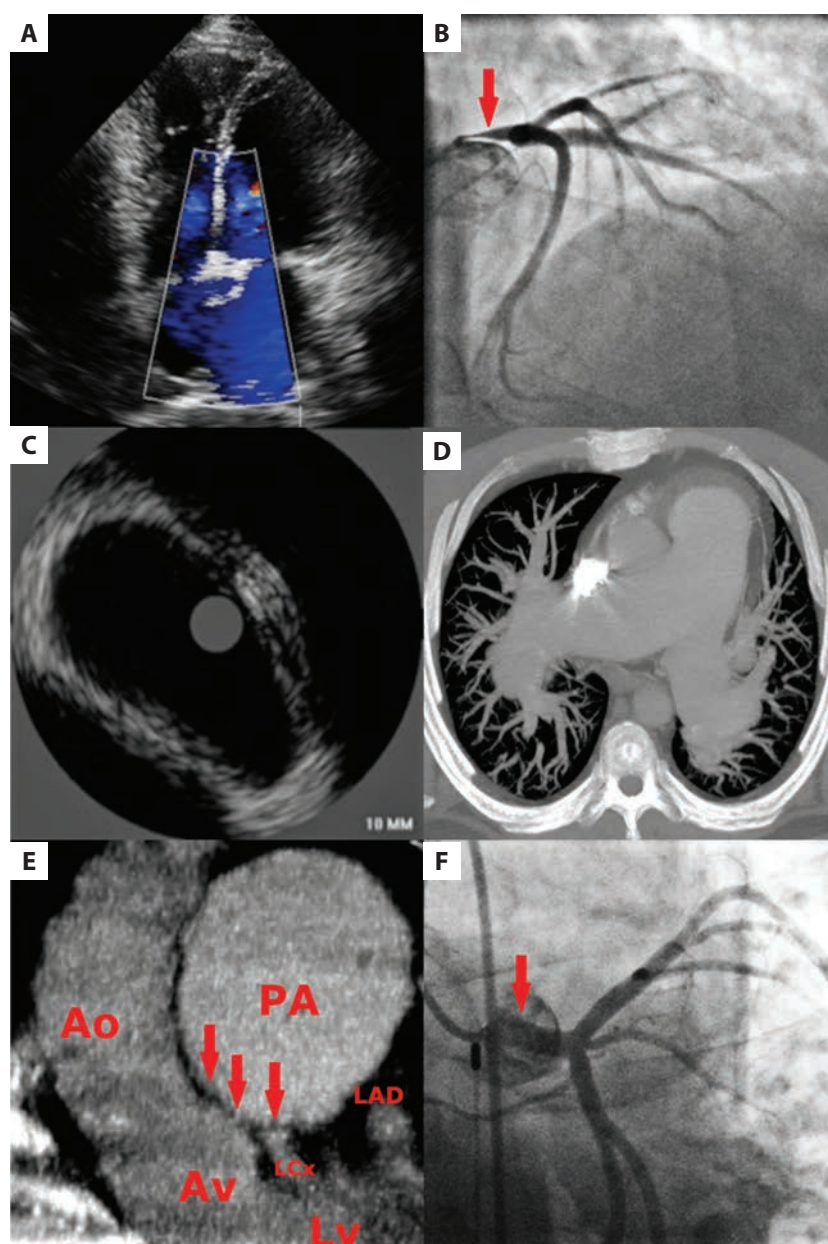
A. Echocardiography with color Doppler showing right ventricle enlargement and bidirectional flow in atrial septal defect type 2. B. Coronary angiography which raised suspicion of significant stenosis in the proximal part of the left main coronary artery (red arrow). C. Intravascular ultrasound demonstrating the elliptical shape of LM without atherosclerotic lesions.
